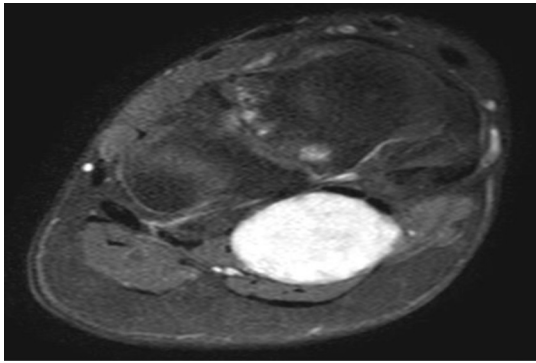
MRI scan showing a 4.5 × 3.5 cm tumour arising from medial plantar nerve.
